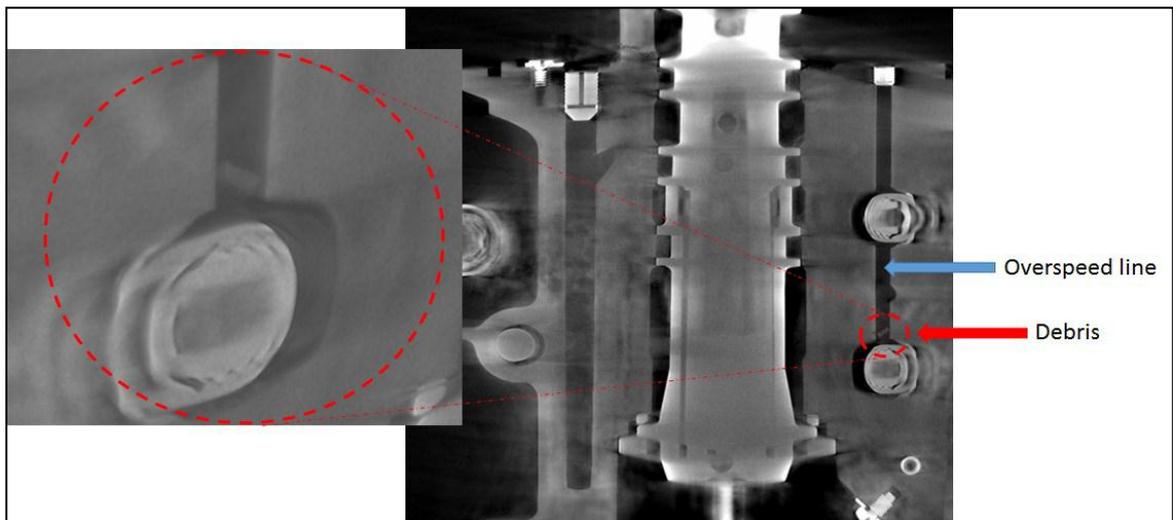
CT Scan of PVM - Debris inside the Overspeed Line
